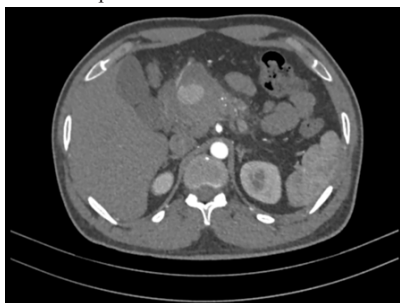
Axial image of contrast enhanced CT examination shows intrapancreatic pseudocyst with pseudoaneurysm supplied by GDA as one of the extra pancreatic complications of acute pancreatitis.
